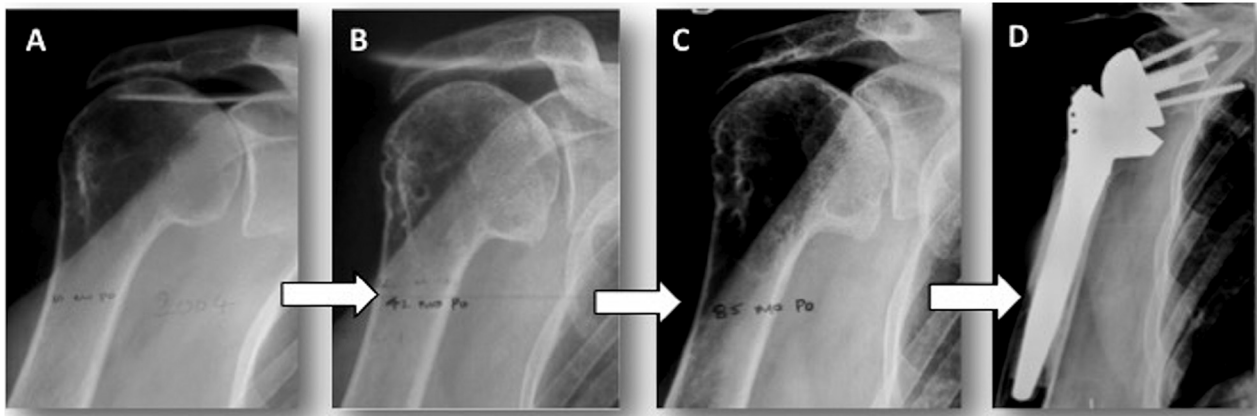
An example of progressive deterioration of the clinical and radiologic results 7 years after L'Episcopo transfer. (A) Preoperative radiograph demonstrates some acetabulization of the acromial arch and some glenohumeral joint narrowing (Hamada grade 4). (B and C) Postoperative radiographs show progressive deterioration of the glenohumeral joint. (D) Seven years after the tendon transfer, the patient was reoperated on for implantation of a reverse shoulder prosthesis and had a good functional result.
